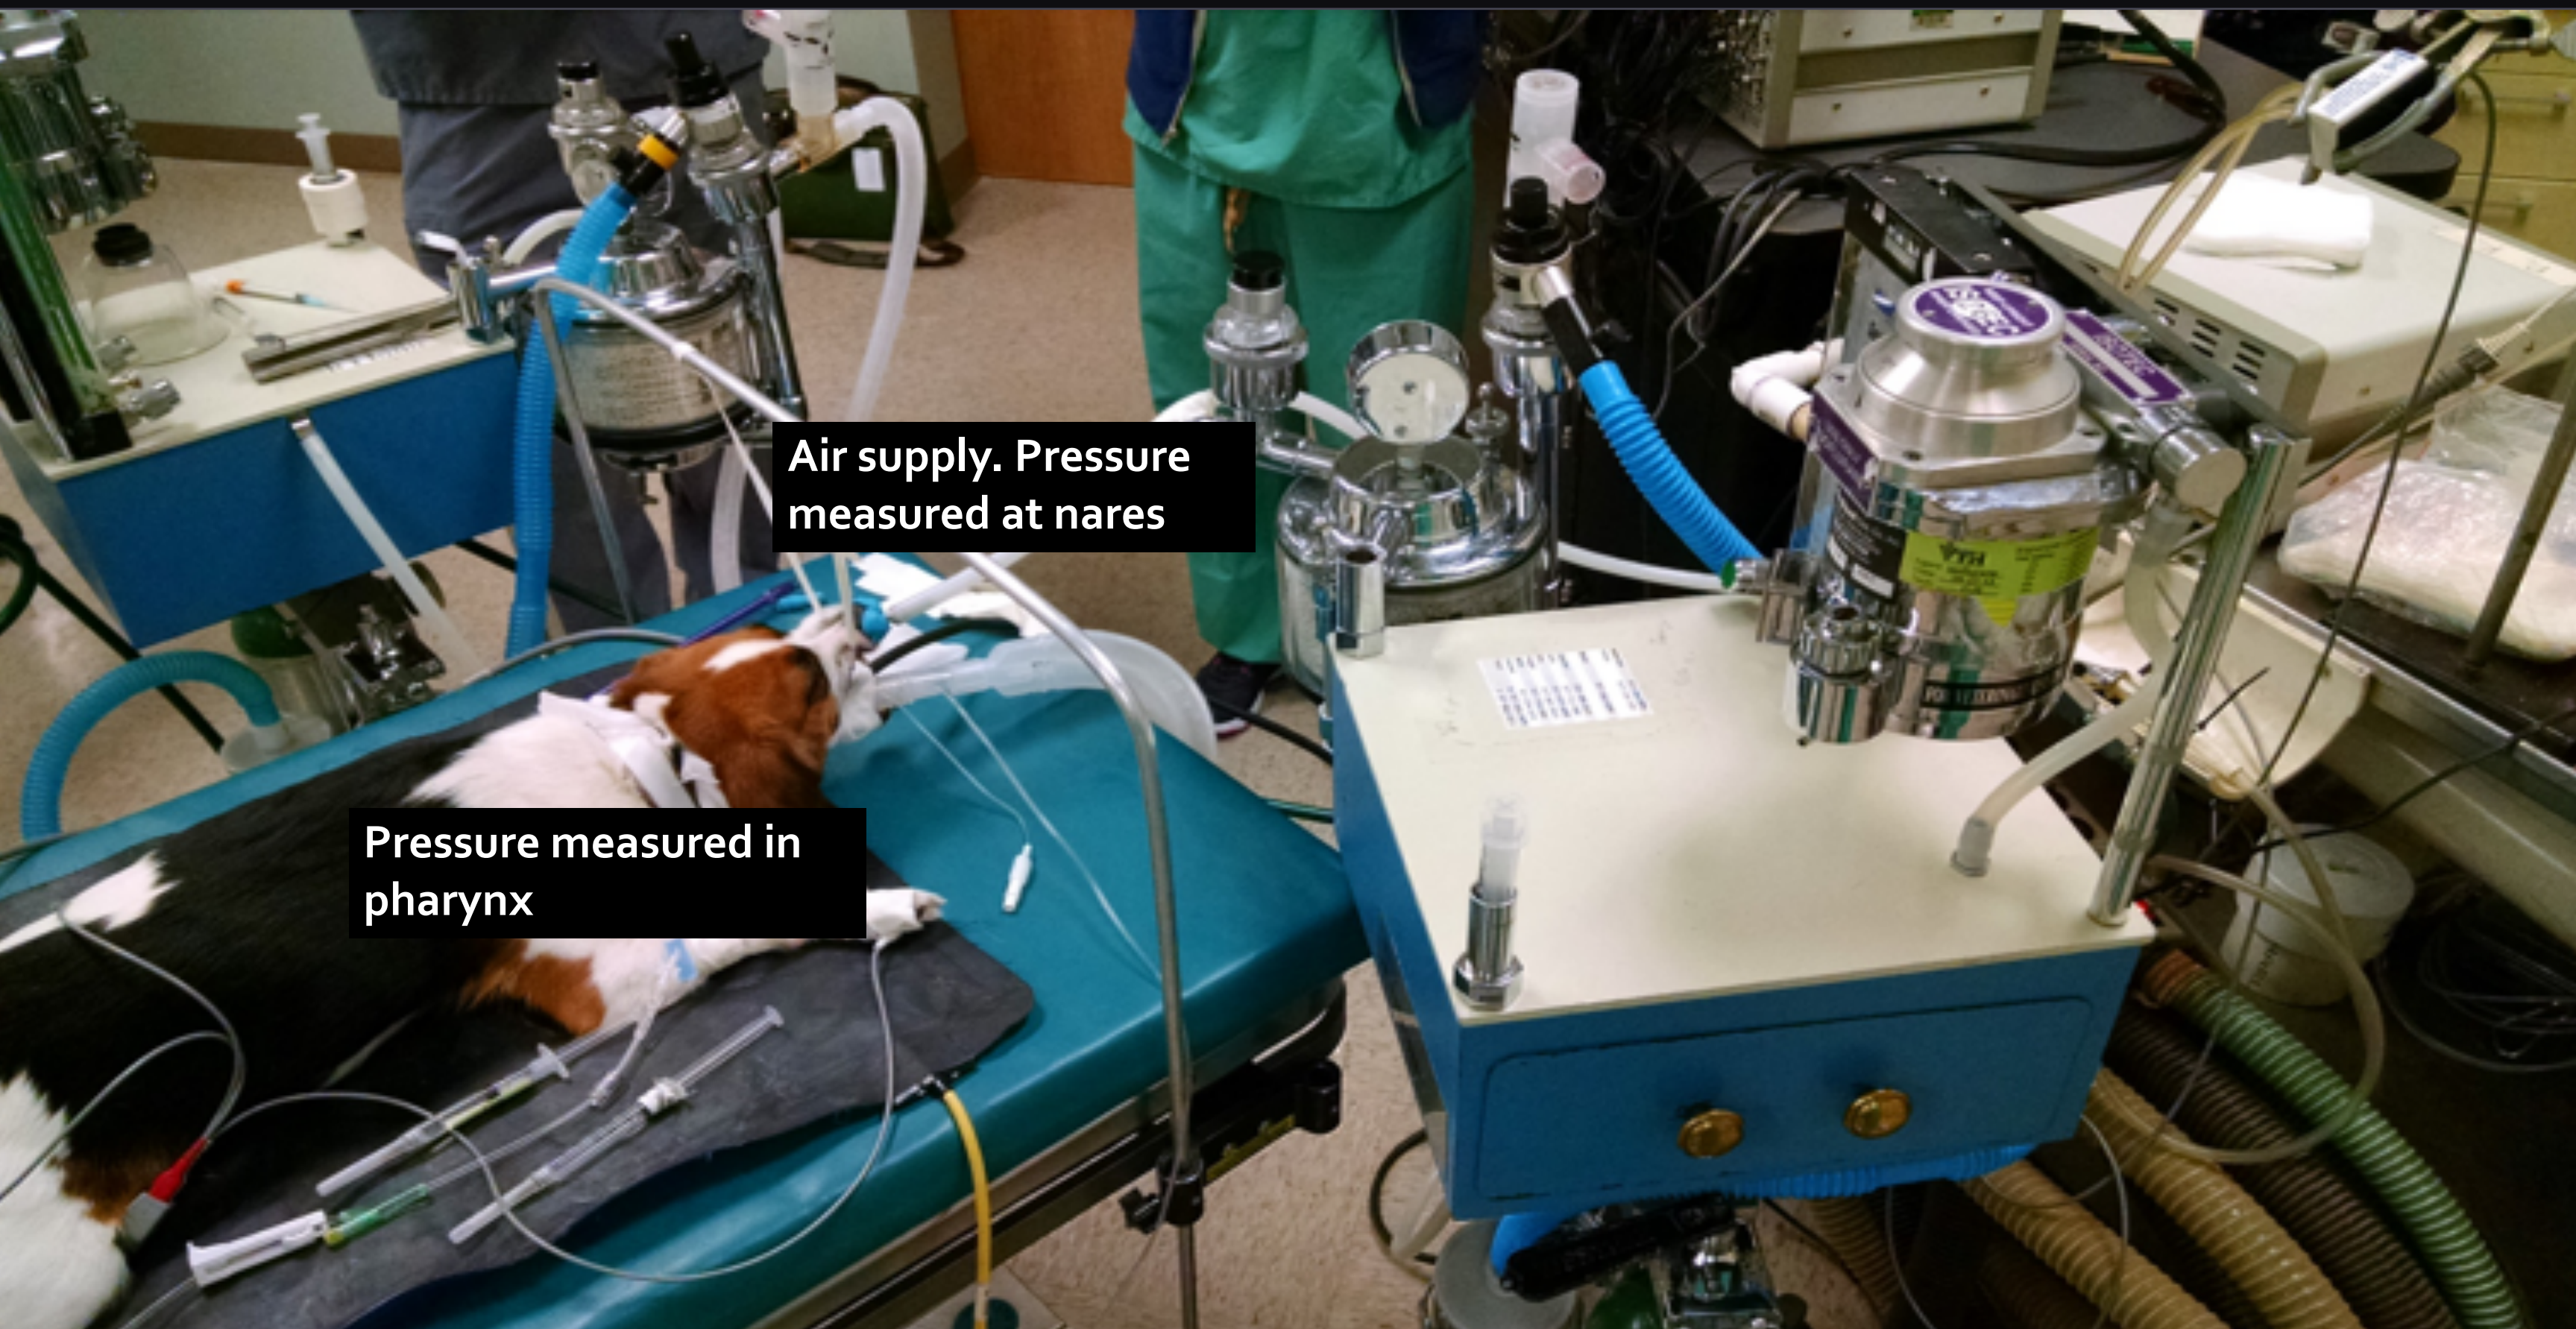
Rhinomanometry being performed on a mesaticephalic breed. Nasal impedance will be correlated to nasal CT images. These data will be compared between NT, Norfolk terriers, brachycephalic breeds and mesaticephalic breeds.
